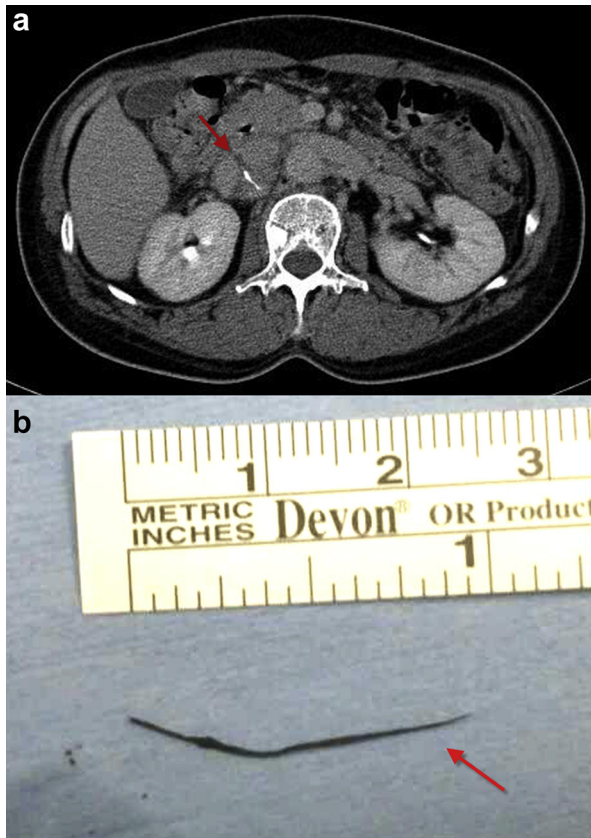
a, Computed tomography (CT) showing a linear, high-density material penetrating the juxtarenal inferior vena cava (IVC). b, A metallic foreign body was retrieved from the confluence of the posterior wall of the right renal vein and IVC. It was later confirmed to be a part of an acupuncture needle.
